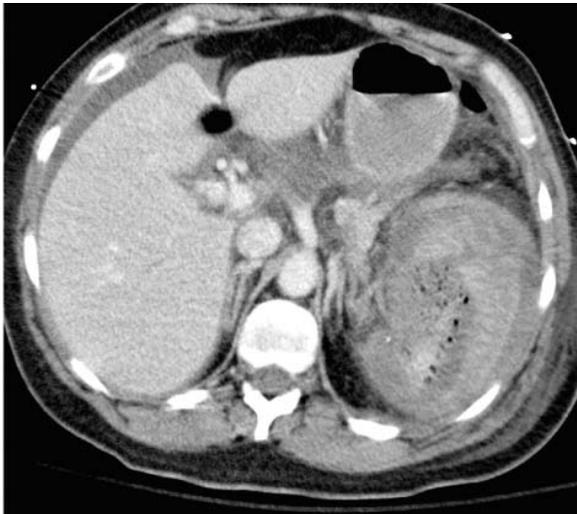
CT scan one day following Gelfoam embolization of the same patient as in Figure 1, demonstrates resolution of the active extravasation and multiple small air bubbles in the spleen due to the Gelfoam material. This appearance is not indicative of an abscess, and this patient had an uneventful recovery with successful splenic salvage.
